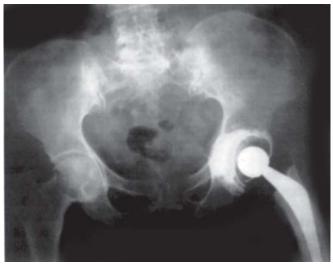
Plain X-ray of THR
